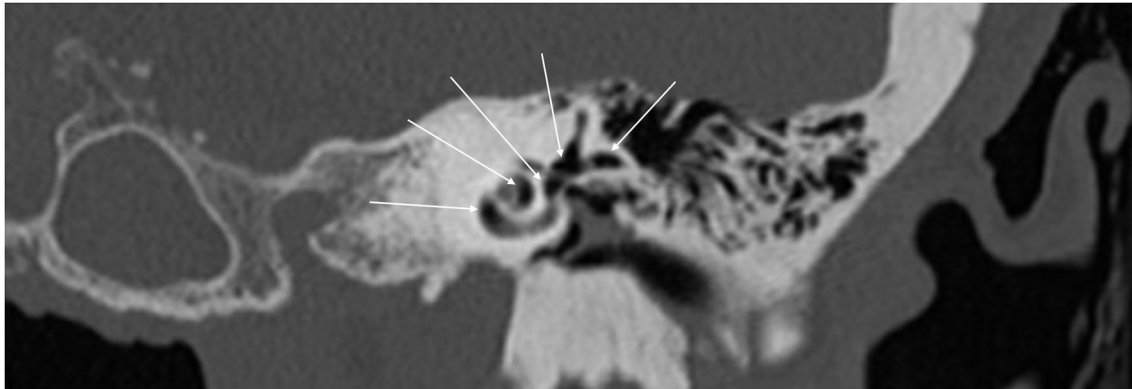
Coronal CT of temporal bone showing extensive air in the cochlea, superior canal, horizontal canal, and vestibule (arrows).
